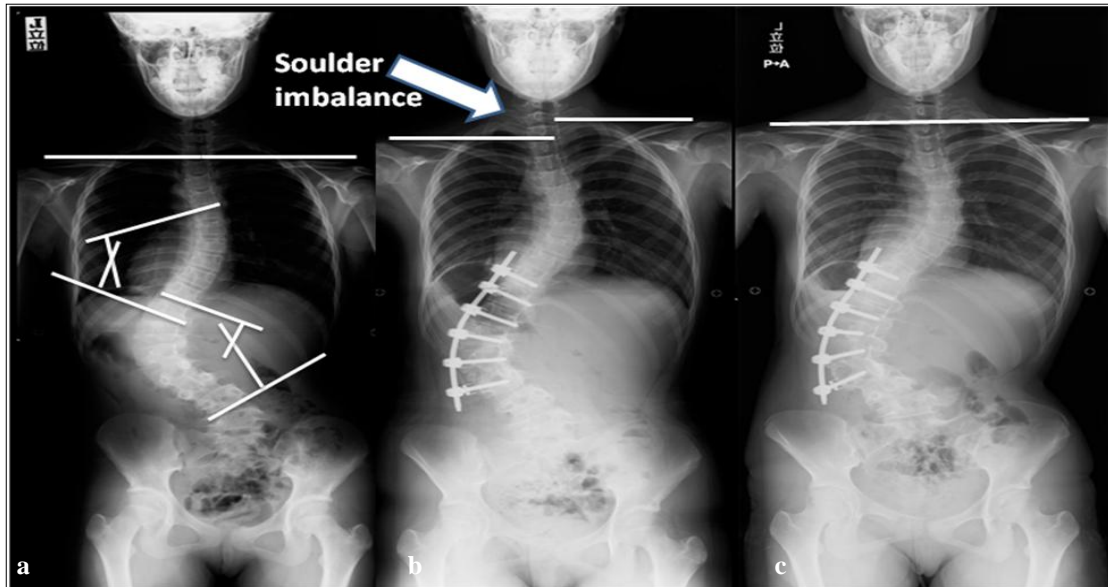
Shows 10 years female patient with Lenke 6CN AIS; a. pre-operative x-ray showing leveled both shoulders, T1 tilt= 0°, FRA= -2°,CA= 0°,CPH= 2 mm, CRCI= 3 mm, Lumbar Cobb angle =79°, Thoracic Cobb angle= 40°, b. post -operative (3 months) showing shoulder imbalance with elevated right shoulder, T1 tilt= -5°, FRA= -3°,CA= -5°,CPH= -21mm, CRCI= -10 mm, Lumbar Cobb angle =62°, Thoracic Cobb angle= 43°, c. post-operative (12months) shoulder rebalance with restoration of shoulder height equality,T1 tilt= 0°, FRA= 0°,CA= 0°,CPH= 3 mm, CRCI= 0 mm, Lumbar Cobb angle =62°, Thoracic Cobb angle= 34°.
